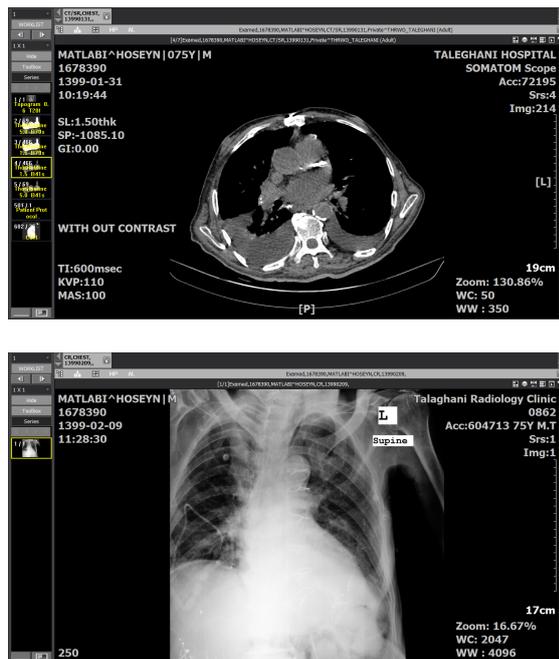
Graphics and CT scan of the lungs of a patient suspected of having a covid-19 disease. He had a history of diabetic foot from two months ago. He was admitted to hospital with lung lesions and was treated for diabetic foot ulcers and subsequent amputations. At the next visit, about two weeks later, the patient developed severe pleural effusion in the right lung. They underwent pleural catheter insertion and drainage fluid. Severe shortness of breath did not occur in this period and he did not require oxygen.
